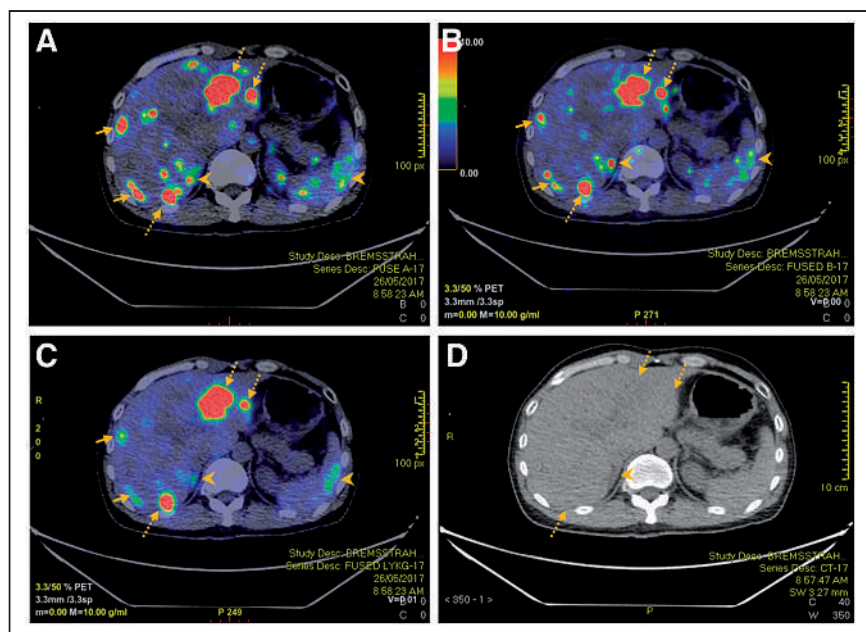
A 52-y-old man with rectal neuroendocrine cancer metastatic to liver underwent ^{90}Y -PRRT therapy. Reconstructed PET/CT using algorithms A (A), B (B), and C (C) managed to detect hepatic metastases (dotted arrows) seen on corresponding CT images (D). However, there was more visible noise within liver for PET using algorithms A and B than for PET using algorithm C (solid arrows). In addition, extrahepatic noise such as that in right adrenal gland and spleen (arrowheads) was less apparent using algorithm C. Right adrenal noise can potentially be mistaken as hepatic metastasis using algorithms A and B (arrowheads).
